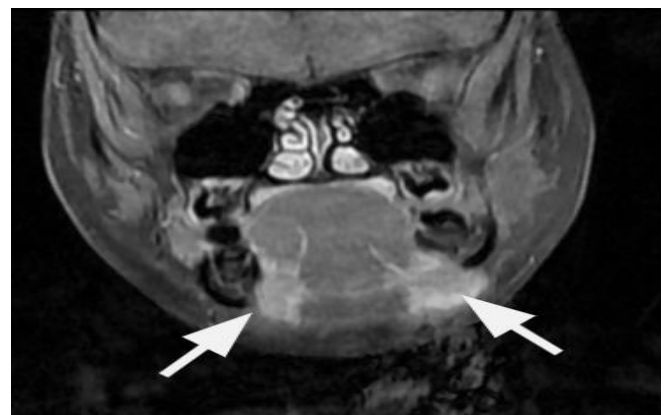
Coronal contrast enhanced T1FS MR image showing bilateral hypertrophied sublingual glands (arrows)
